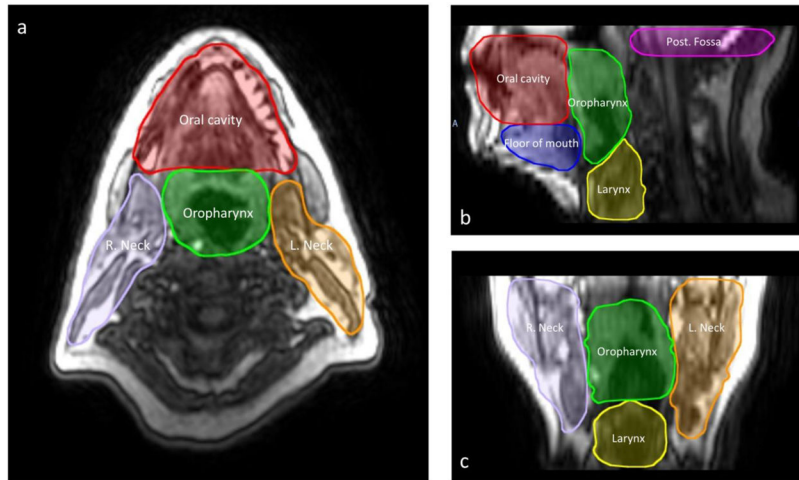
(a) Axial, (b) sagittal, and (c) coronal DCE-MRI of a head and neck patient, with the reference ROIs for tracking motion trajectory.
